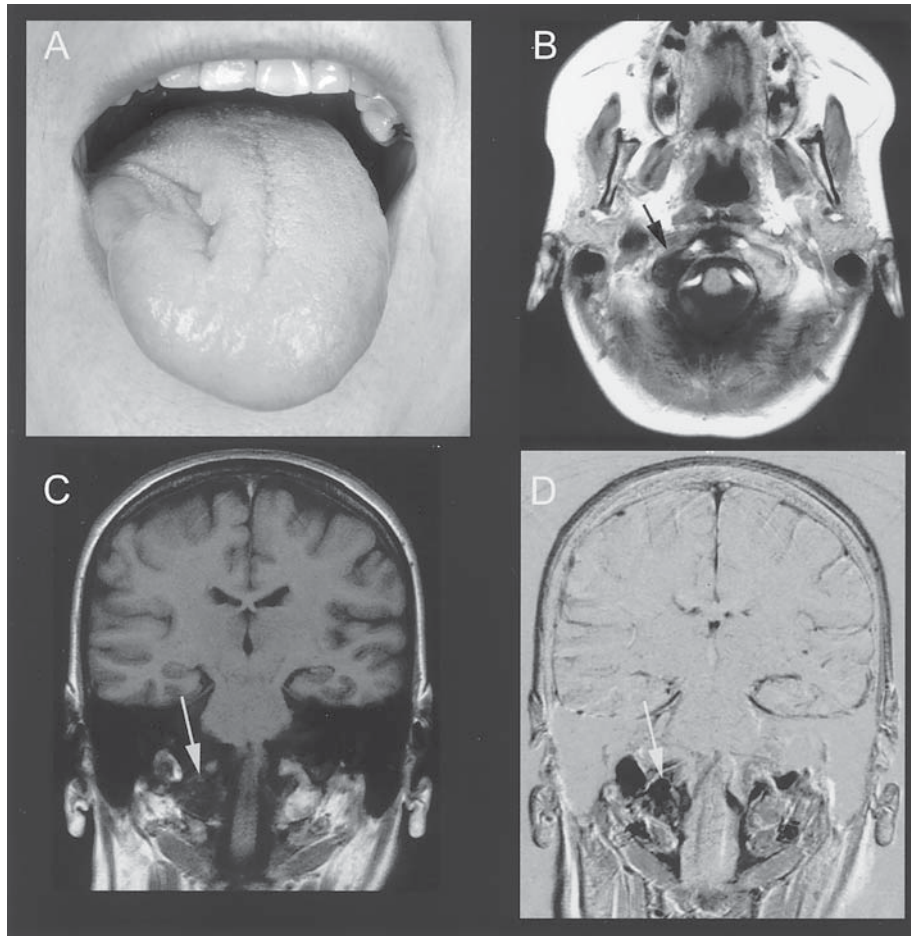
A woman with known metastatic breast cancer presented with slurred speech and right-sided occipital headache. On examination the tongue deviated to the right and was atrophied on that side (A). T1 weighted MRI images demonstrate a metastatic lesion at the right occipital condyle (arrow) compressing the XIIth cranial nerve in the hypoglossal canal (B,C). MRI subtraction images demonstrate enhancement of the bony lesion after gadolinium administration (D).
